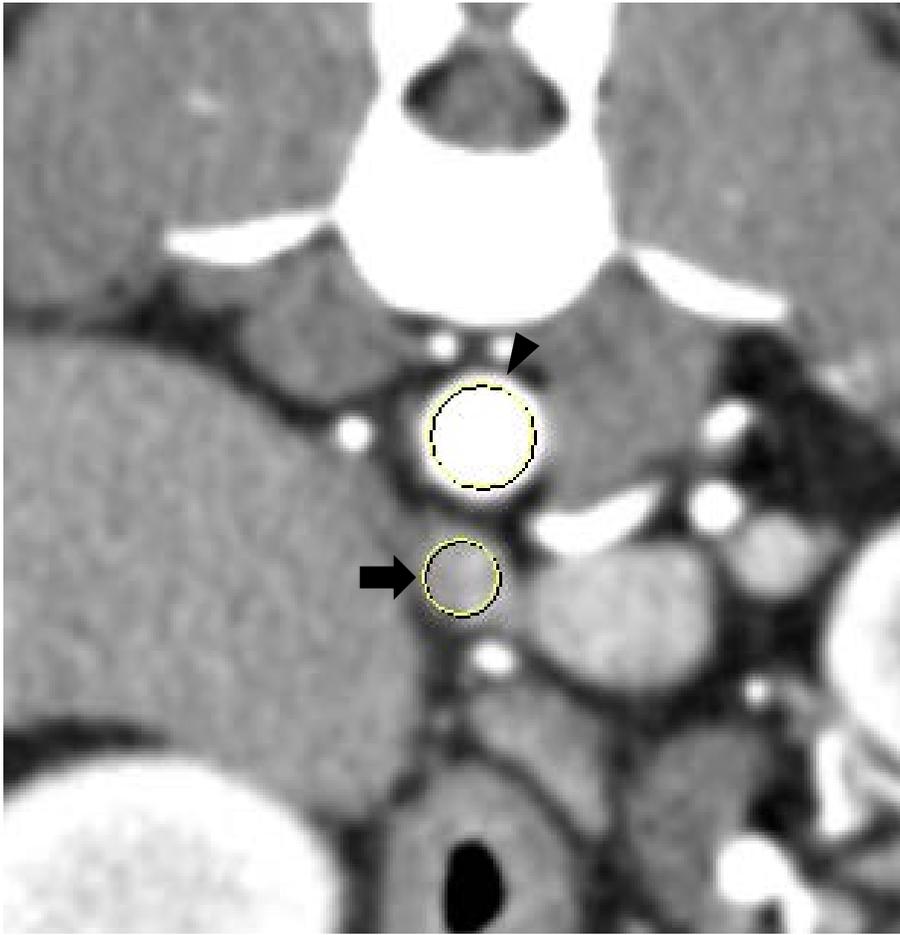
ROI was drawn on each dynamic CT image included at least one-half of the area of the adrenal gland (arrow) excluding gland edges. In the same image, another ROI was drawn in the aorta (arrow head).
